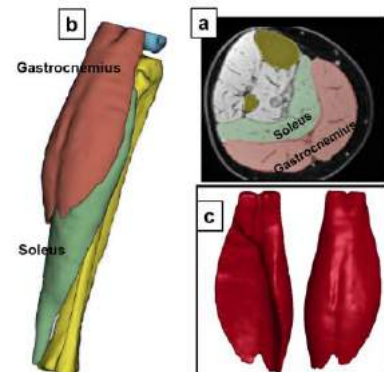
a) Axial MRI image, b) Segmented volume in 3D slicer, c) Gastrocnemius muscle front and back views
